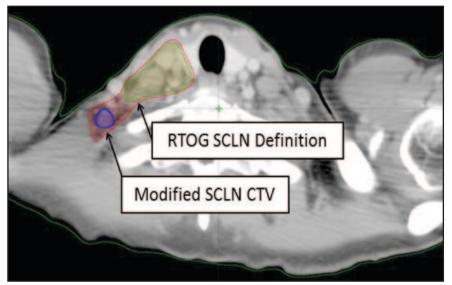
Treatment-planning CT scan for inflammatory breast cancer patient evincing inadequate CTV coverage of posterior-lateral SCLN (blue), contoured by The RTOG Contouring Atlas definition (green), with suggested modifications (red).
